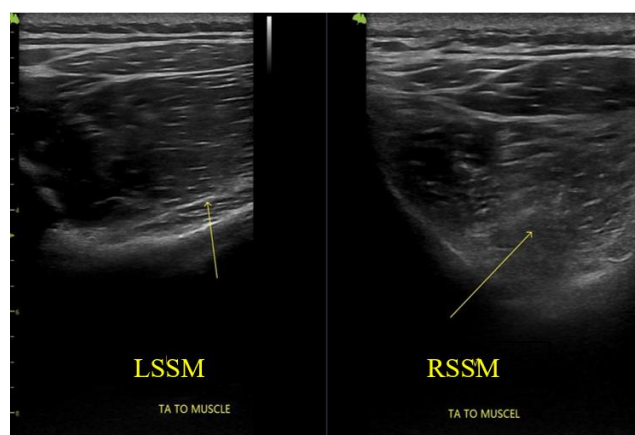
An ultrasound of the left supraspinatus muscles (LSSM) and the right supraspinatus muscles (RSSM) along the Transvers axis (TA). Normal muscle pattern in left side and fatty infiltration and atrophy of Grade 1 in right side.
